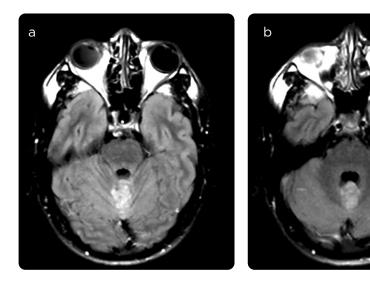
Multinodular images, coalescing images in the central region of multi-cystic appearance, with high signal in T2-FLAIR sequence.
